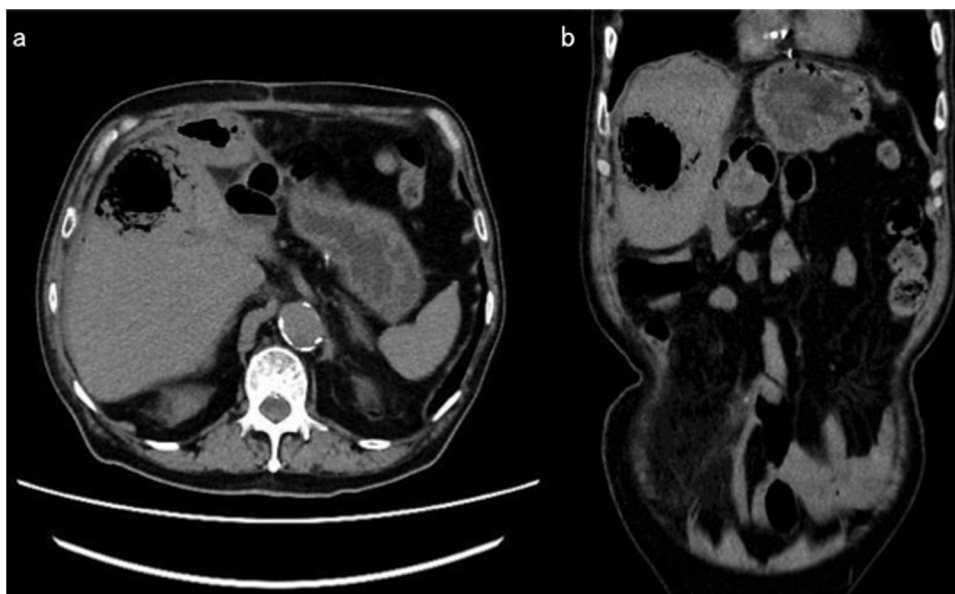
Abdominal CT scan showing a 48 mm × 46 mm air accumulation in the anterior segment of the liver. Portal gas formation is seen. (a; axial view. b; coronal view.)
